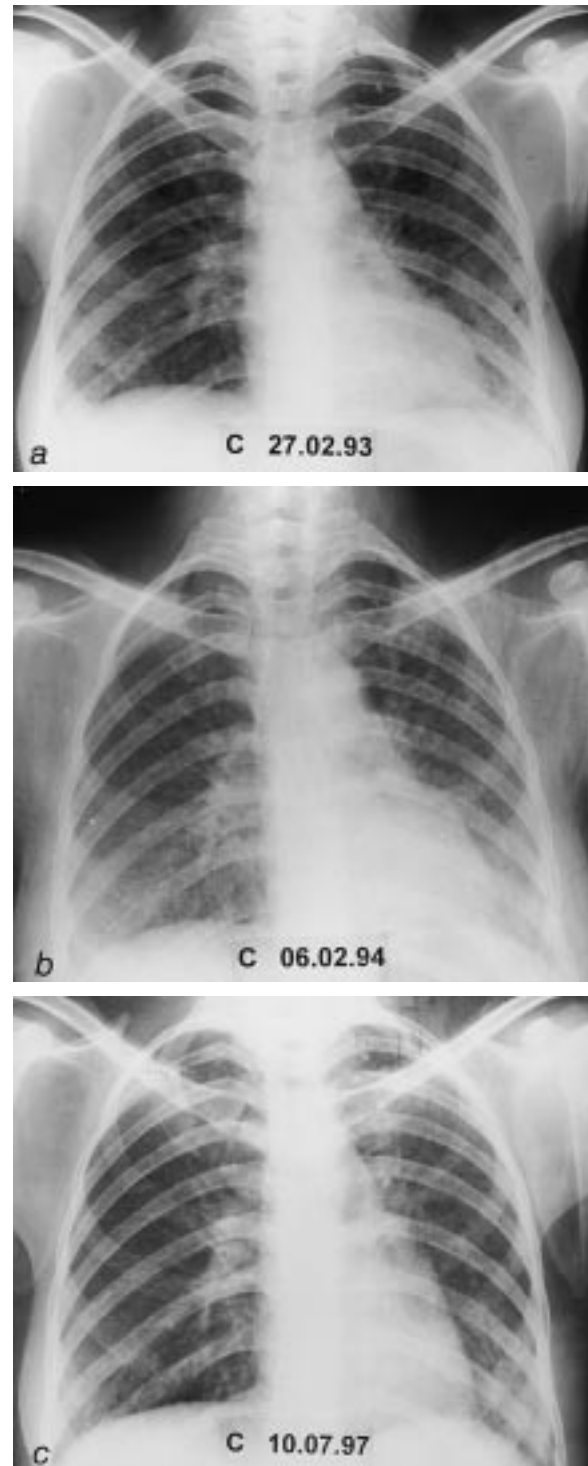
Successive chest radiographs for patient C at: a) presentation; b) 1 yr later; and c) 4.5 yrs later.
